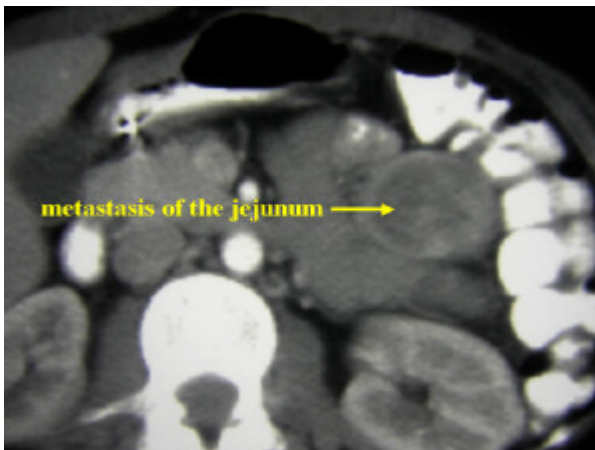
Abdominal CT scan of the metastasis in the jejunum.
